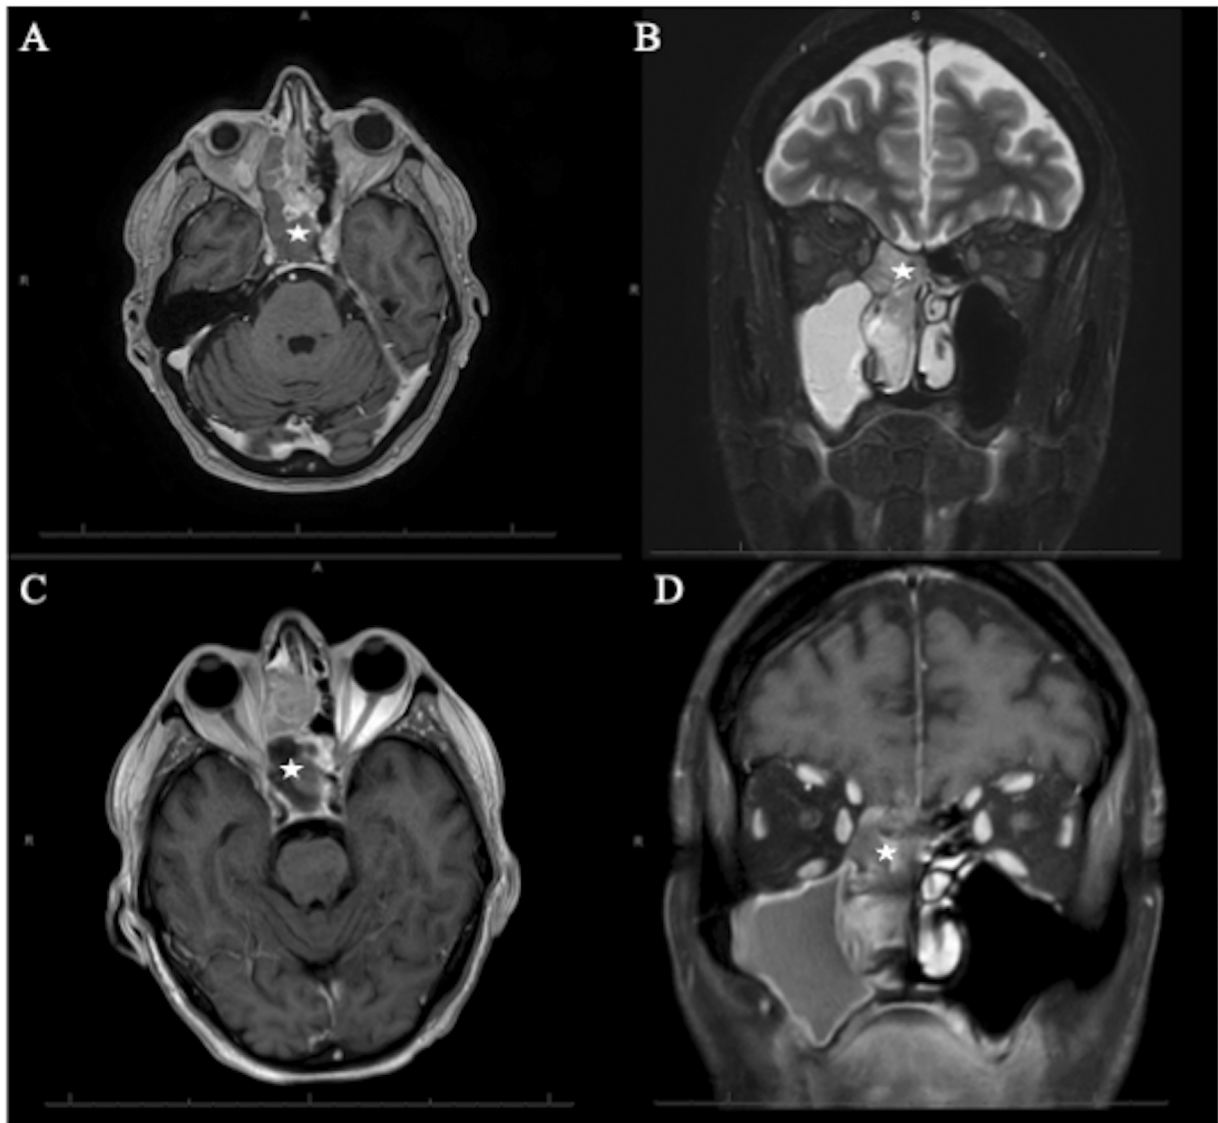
Pre-treatment computed tomography (A) and magnetic resonance imaging (MRI) (B) images of right nasal cavity sinonasal undifferentiated carcinoma (star) with extension into ethmoid, sphenoid, and frontal sinus and through cribriform plate. Postinduction chemotherapy MRI (C, D) of same patient shows no significant reduction in tumor size.
